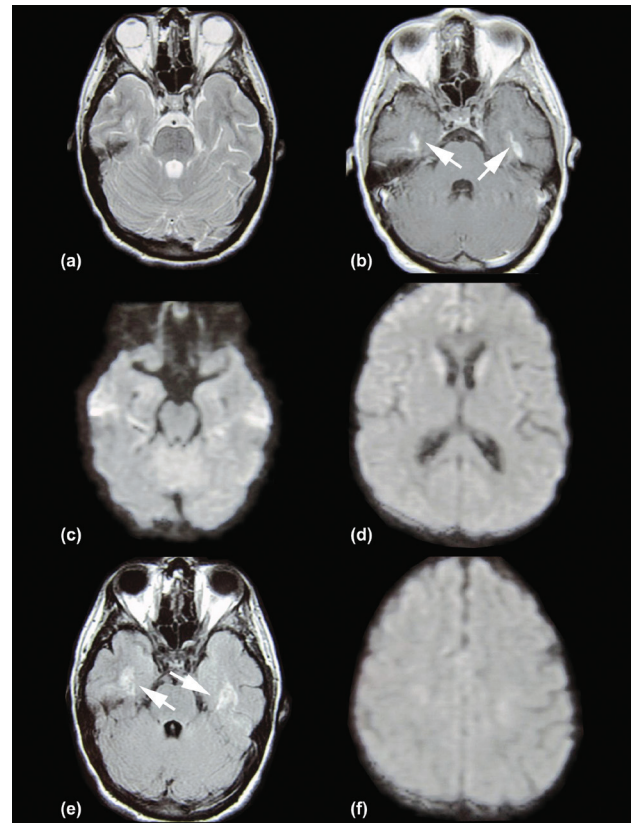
MRI performed after 13 days of hospitalisation: (a) Axial T2W image showing no hyperintensity. (b) Contrast-enhanced axial T1W image demonstrates mild residual enhancement in the temporal lobes (c) Axial DWI shows no restriction of diffusion in the temporal lobes, in the right occipital lobe and splenium (d) and in the centrum semiovale (f), (e) Axial FLAIR image shows mild residual hyperintensities in both temporal lobes (corresponding areas indicated with arrows).
